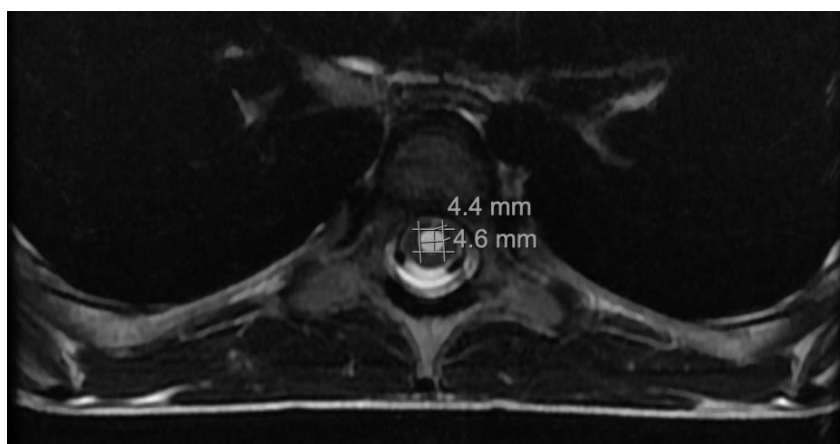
MRI Spine axial view of thoracic syrinx with measurements.
